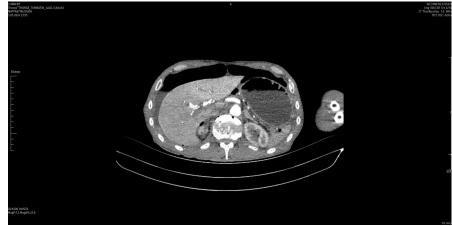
In abdominal CT with contrast, free fluid and free air are observed in all quadrants of the abdomen. The image also highlights an edematous apperance of gastric wall distal to the stomach.
